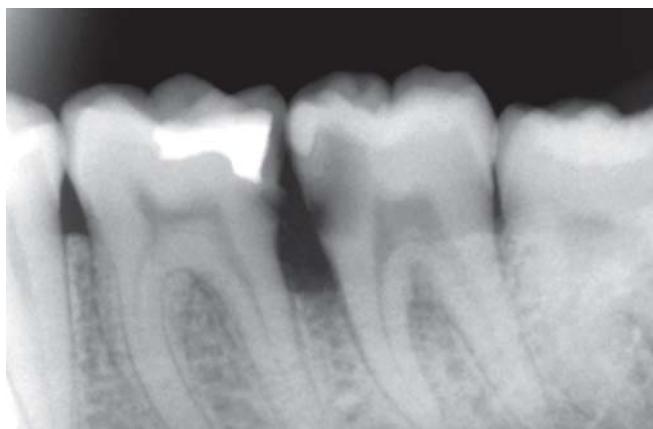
Radiograph showing secondary caries
